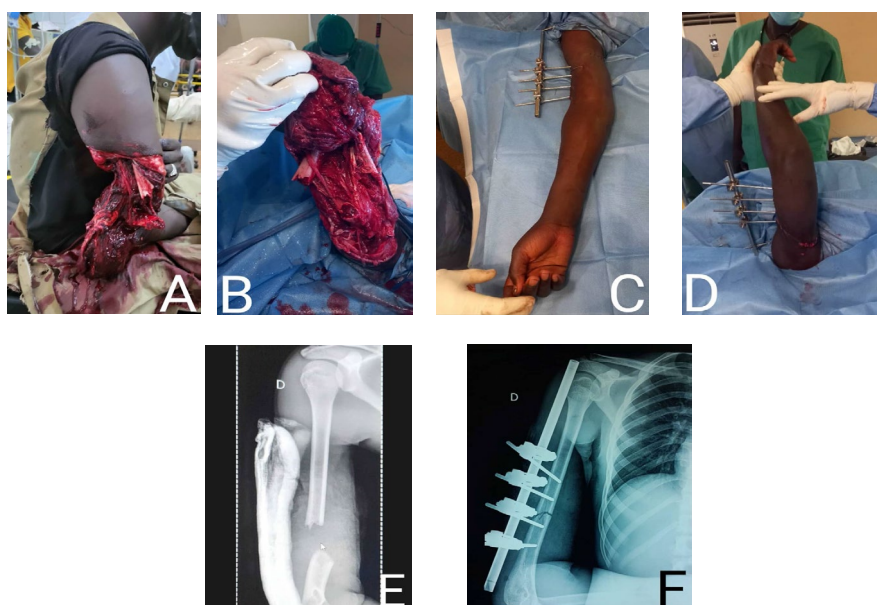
A 20-year-old adult, right-handed, who was involved in a road traffic accident involving a car and a motorbike, resulting in an open fracture of the right humerus classified as type IIIA according to Gustilo and Anderson, without downstream neurovascular disorders. A) Image taken at the scene of the accident, B) Intraoperative image following debridement, C, D) Anterior and posterior views of the limb following reduction and humerohumeral external fixation and E, F) Standard anteroposterior radiographs (pre-treatment and follow-up) showing a simple fracture of the junction between the proximal and middle thirds of the right humerus, with a transverse line and elongation, and an external fixator securely in place with anatomical reduction.
